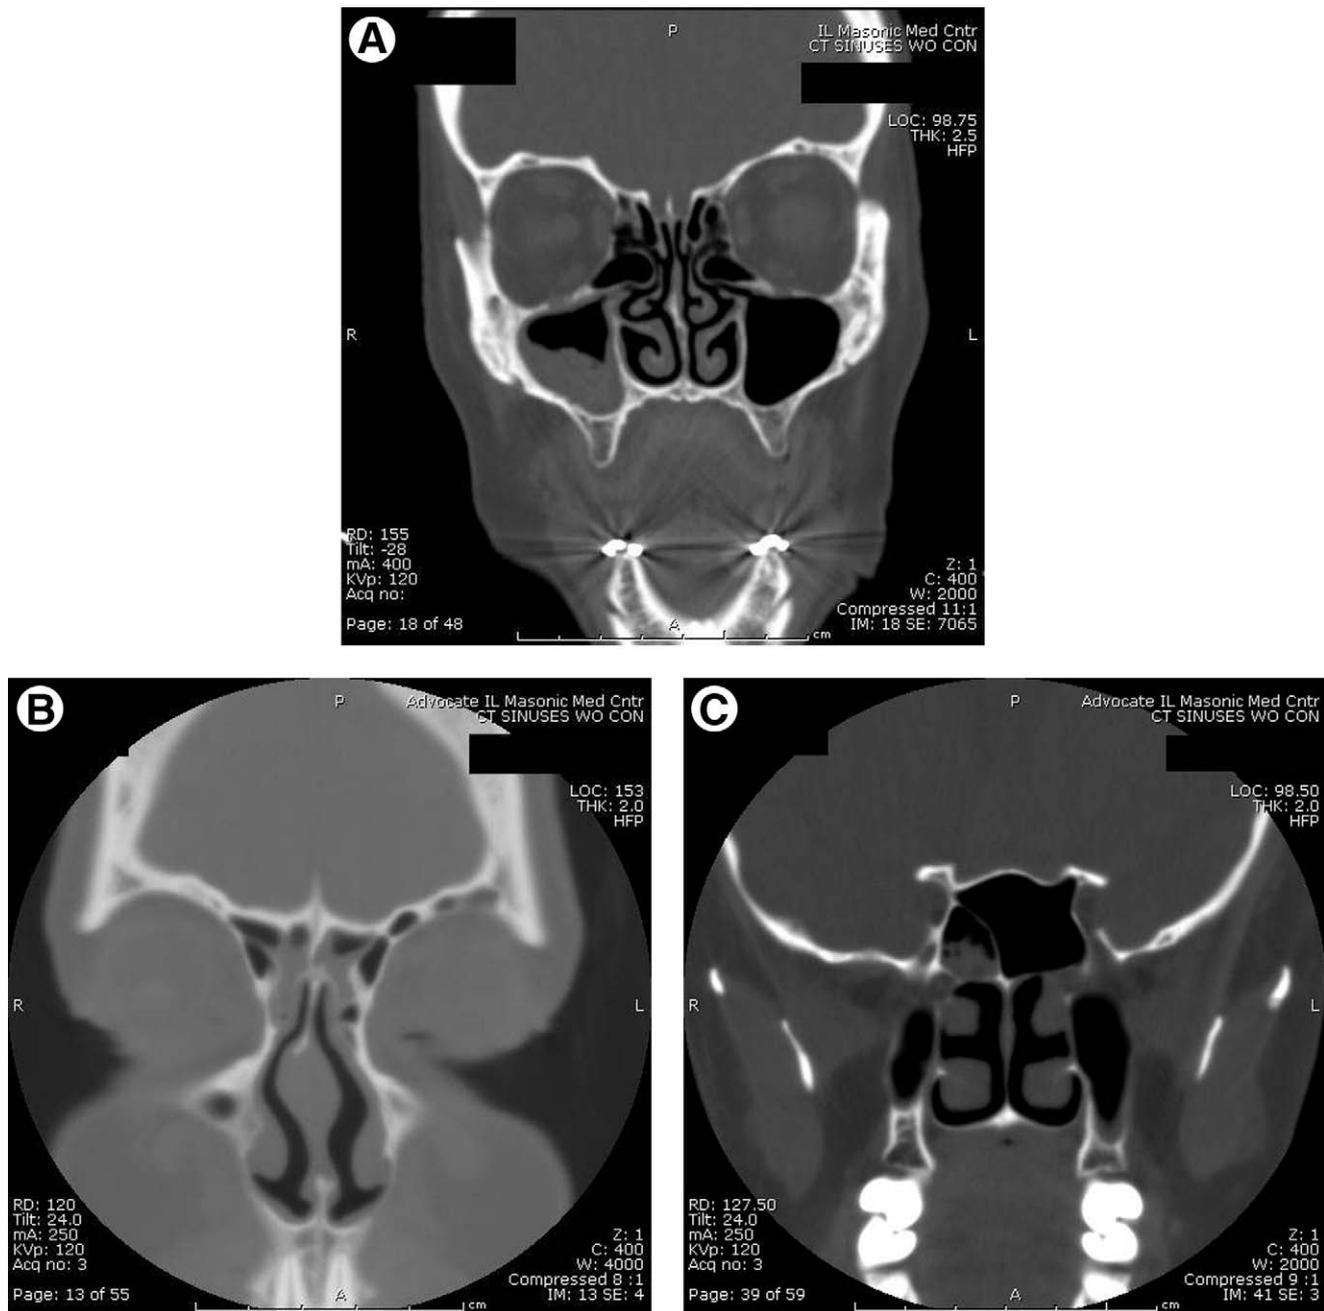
Noncontrast CT of the sinuses showing sinusitis of the right maxillary sinus (A), sinusitis of the bilateral frontal sinuses (B), and sinusitis of the right sphenoid sinus (C).
